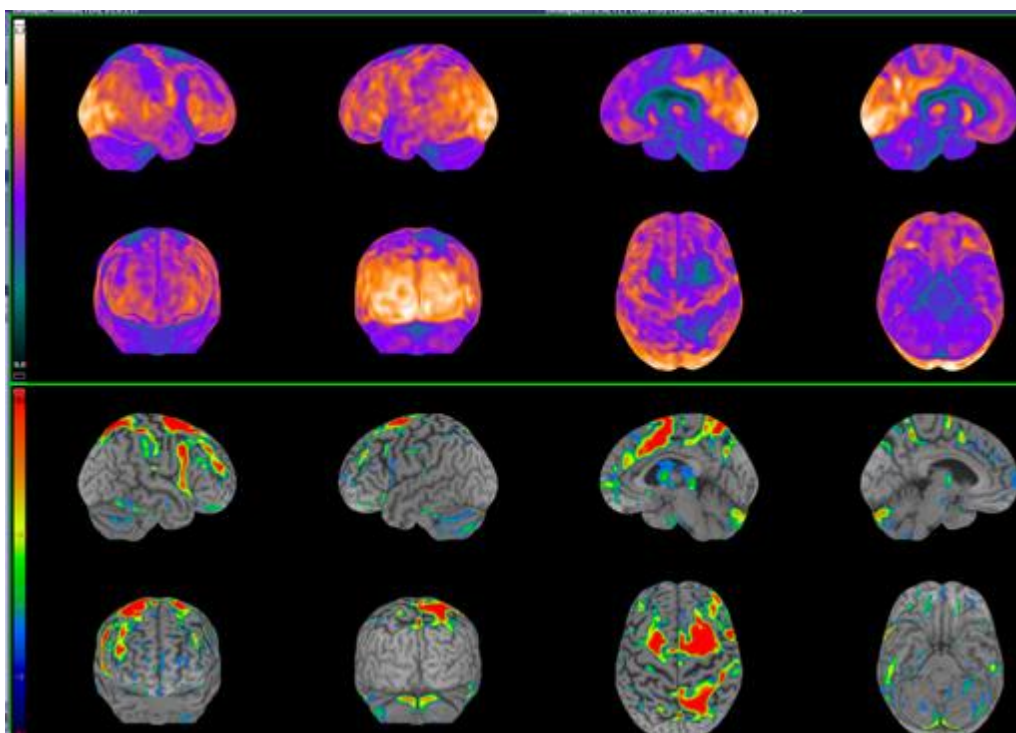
FDG-PET disclosing CBD hypometabolic pattern
